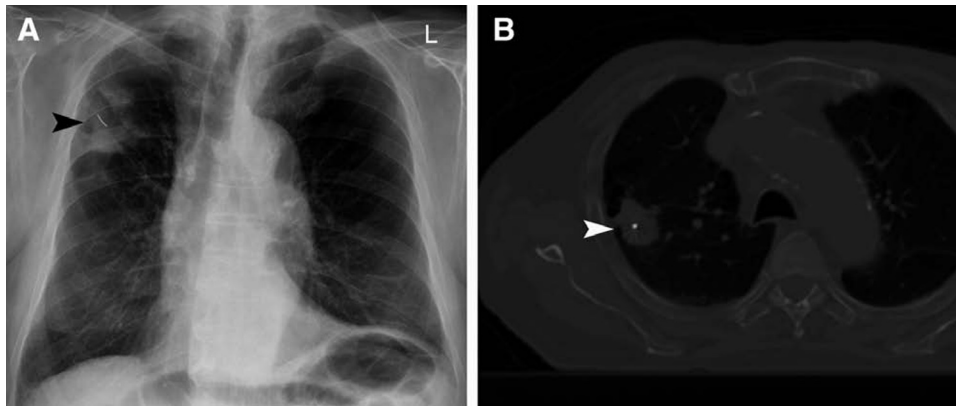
Postprocedure (A) CXR and (B) planning CT, demonstrating successful implantation of fiducial marker within target lesion after EBUS localization of peripheral lung tumor. CT, computed tomography; CXR, chest x-ray; EBUS, endobronchial ultrasound.
